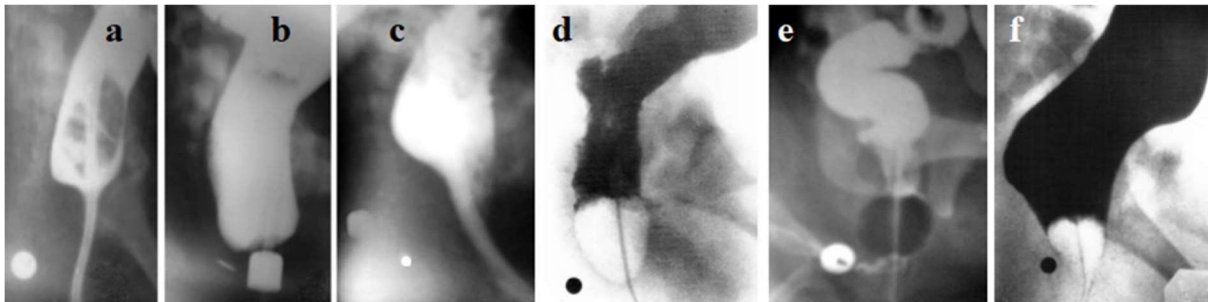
Lateral radiographs of the anorectum in patients with ARMs with visible fistulas. (a-b) Images of the same child taken at different times. (a) A catheter was inserted through the vestibular fistula into the rectum for enter contrast substance into the intestine. At rest, the anal canal is contracted around the catheter. (b) During a follow-up examination, an attempt to defecate resulted in a wide opening of the anal canal. The distance between the marker in the anal dimple and the wall of the opened anal canal is 4 mm. (c) During the administration of barium, relaxation of the IAS occurred, allowing barium to enter the upper part of the anal canal, in front of the rectal tube. At this moment, the posterior wall of the anal canal is pressed against the rectal tube by the contracted PRM. This is an X-ray manifestation of the rectoanal inhibitory reflex. The IAS is fixed to the rigid ring through which it extends outward. (d, e, f) When the anal canal is opened, the distance from the wall of the anal canal to the marker in the anal dimple ranges from 2 to 4 mm, depending on the patient's age [8].
